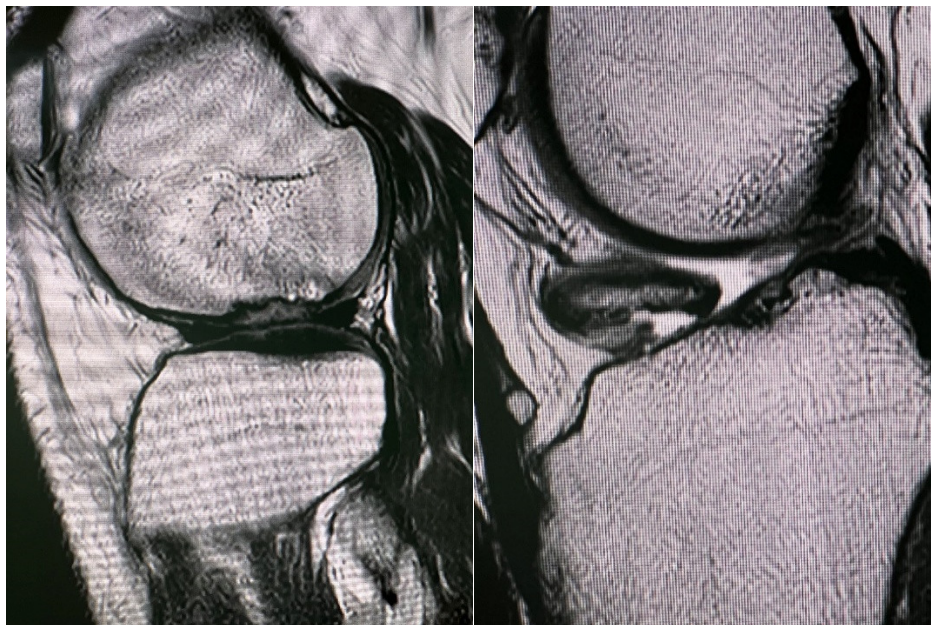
Preoperative MRI showing an osteochondral lesion of the lateral femoral condyle and intraarticular loose body
